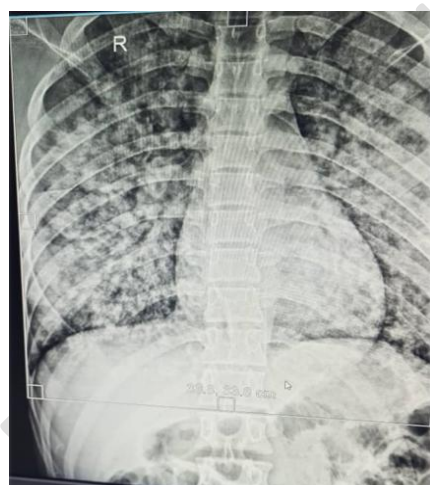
Chest X-ray and lower opacities “Bilateral pleural effusion with % of the lungs are involved.
